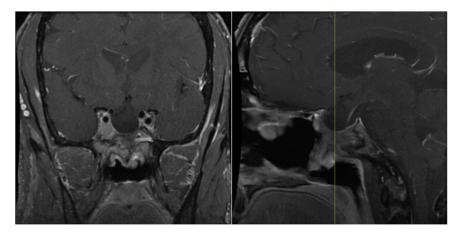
Nine-month postoperative T1-weighted postcontrast magnetic resonance imaging demonstrated area of hypoenhancement that corresponds with residual tumor along the right cavernous sinus in coronal view (left) and relative position (yellow line) of the sella in the sagittal view, which also demonstrated the extent of tumor resection achieved with surgery.
